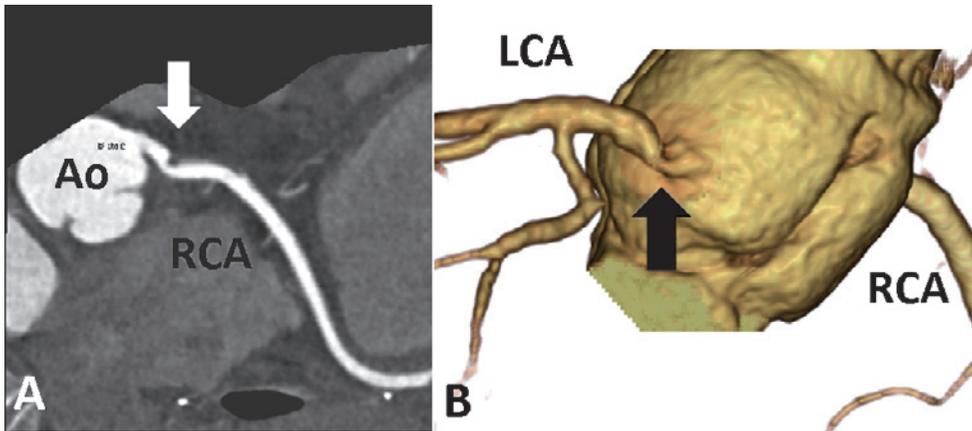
(A) Postoperative computed tomography demonstrated significant stenosis of the right coronary artery interposed with the saphenous vein graft (arrow). (B) Postoperative 3D computed tomography clearly demonstrated significant stenosis of the left coronary artery interposed with the saphenous vein graft (arrow).
